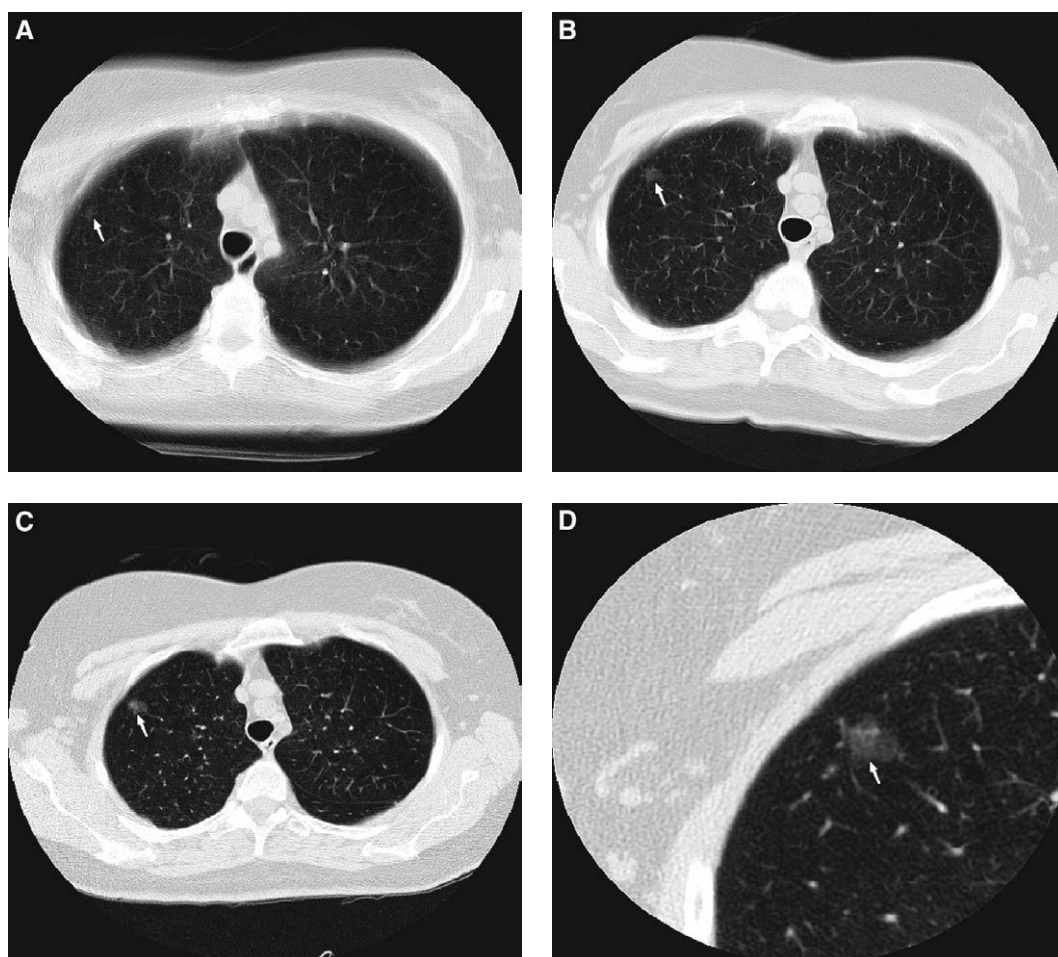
Starting in 1993 CT screening was performed using a 10 mm slice thickness. With advances in technology, thinner slices were obtained while covering the same volume in a single breath-hold. Effect of slice thickness on visibility of a stable nodule: (A) 10 mm slice thicknesses. (B) 5 mm slice thickness. (C) 2.5 mm slice thickness. (D) 1.25 mm slice thickness.
